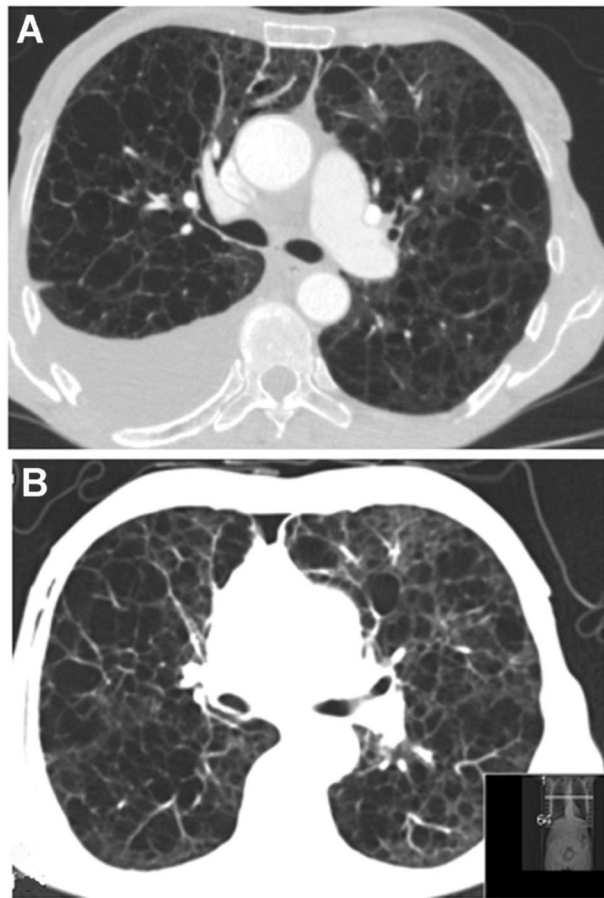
CT scans in 3 patients with lymphangioleiomyomatosis before and after sirolimus therapy
